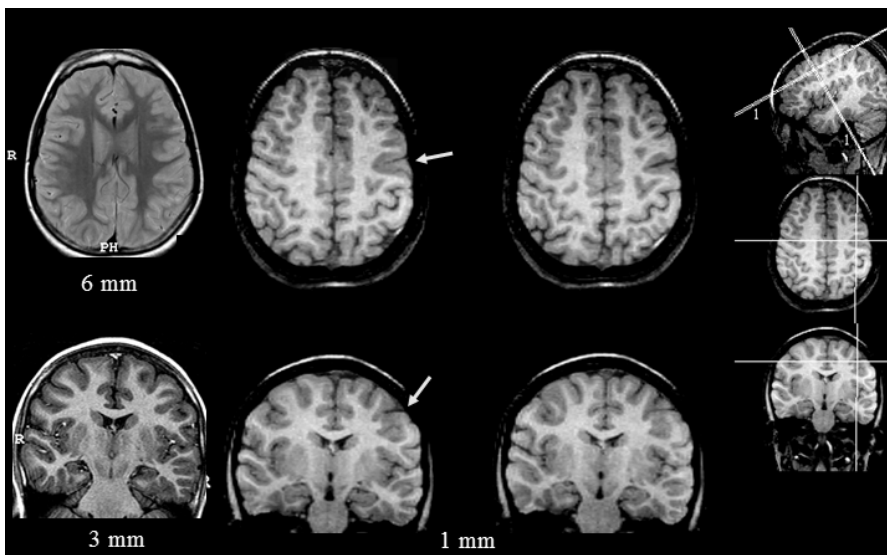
MRI multiplanar reformatting (MPR) showing area of focal cortical dysplasia (arrow) in a 7 years old girl with partial motor seizures starting on her right hand. Conventional MRI with 3 to 6 mm thick slices did not detect the lesion which became apparent in images with 1 mm thick using MPR.
